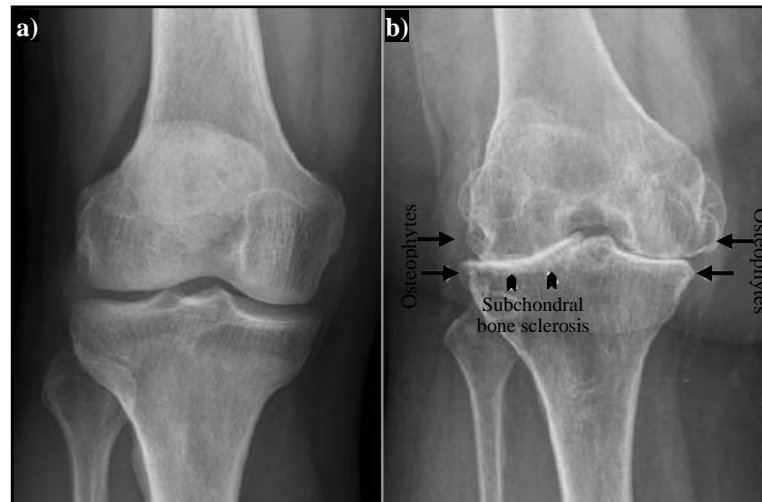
X-ray comparison of: a) normal knee; b) end-stage OA knee, showing complete obliteration of the joint space (Adapted from reference 143).
